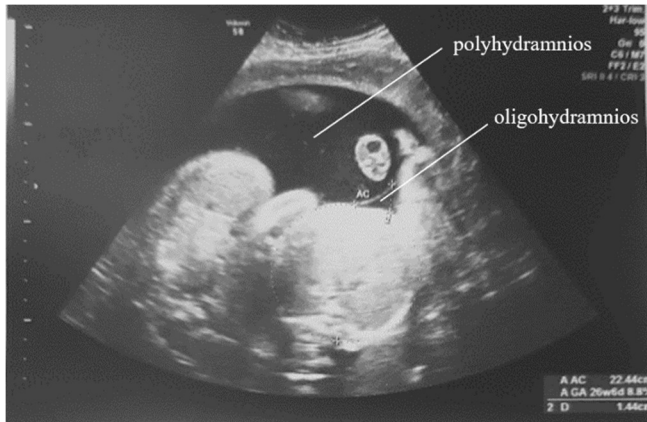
Ultrasound image demonstrating TTTS characteristic findings including polyhydramnios around the recipient twin, and oligohydramnios around the donor twin.
